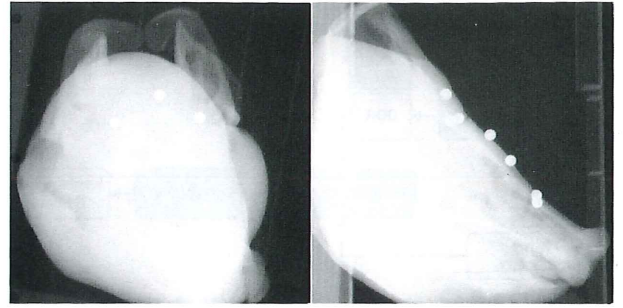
The left and right images respectively correspond to the X-rays from AP and LAT view.
